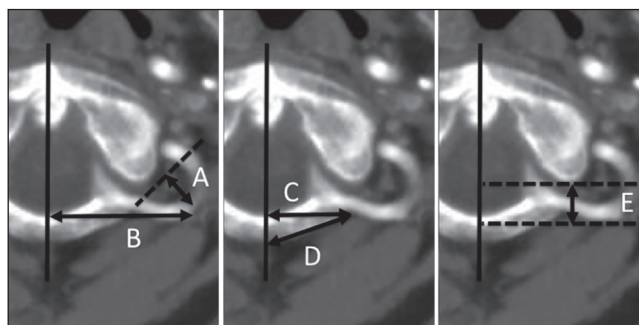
Reconstructed computed tomography angiography (CTA) at the atlas: Arrows in each panel represent the parameters. Five parameters (A, B, C, D, and E) are defined. See Methods for details on the definition of parameters
